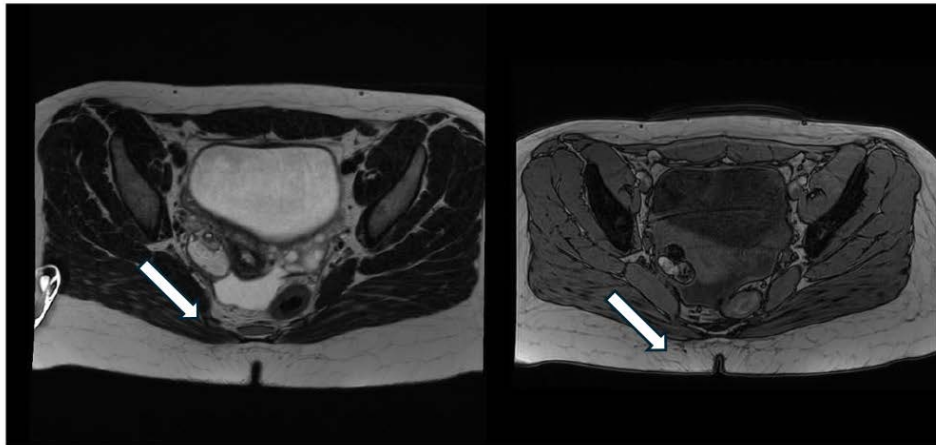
Pelvis MRI (arrow pointing the cyst).
